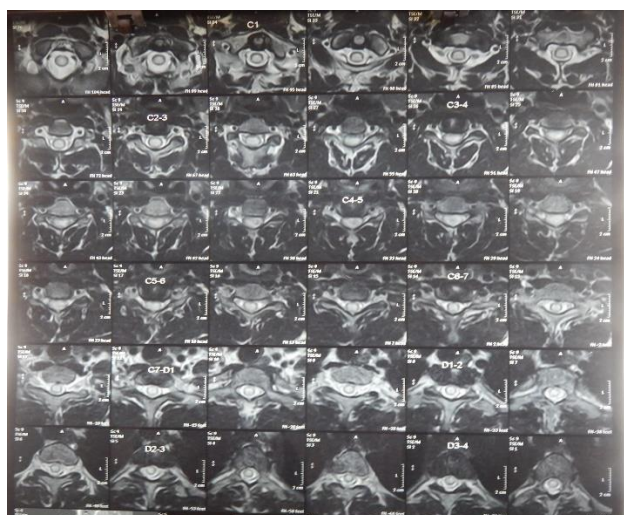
MRI cervical spine axial view.
